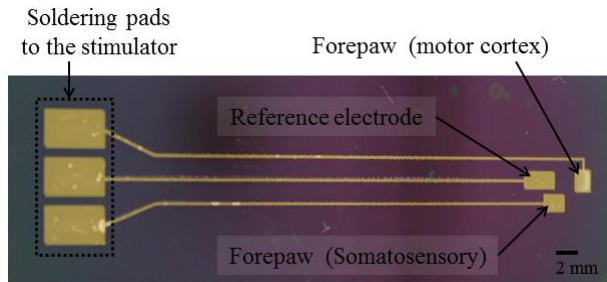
The MRI-compatible, ultra-thin, flexible stimulator array
